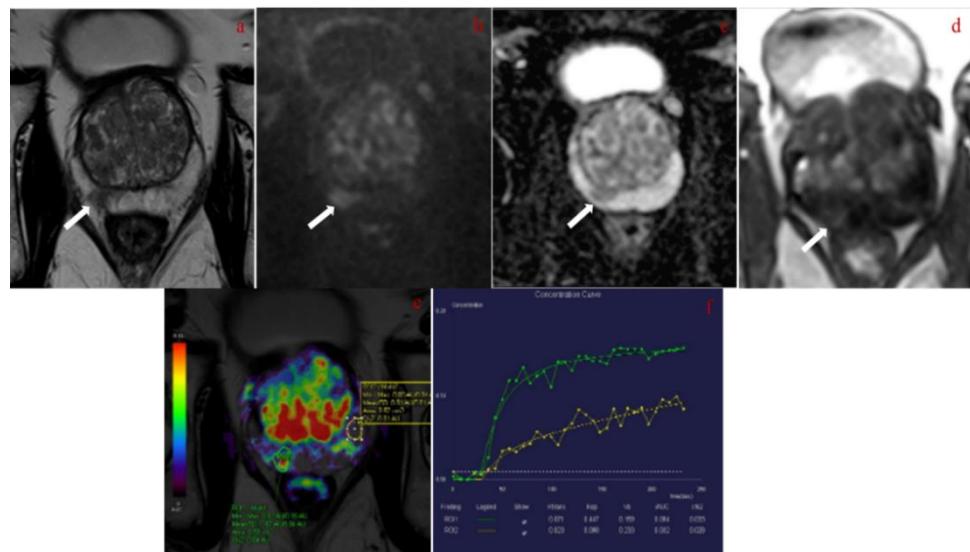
mpMRI images of a 72-year-old patient with PSA 8.55ng/ml and PSAd 0.09ng/ml/cm³; From a to d, axial T2W, DWI, ADC, DMI, and from e to f, perfusion maps measured from lesion and normal tissue. Reader 1, reader 2, and consensus PI-RADS scores were 4, 4, and 4, respectively (white arrows). TRUS cognitive biopsy result was ISUP 1 in the right mid PZ. RP result was ISUP 2, 5% involvement; ie upgraded.
